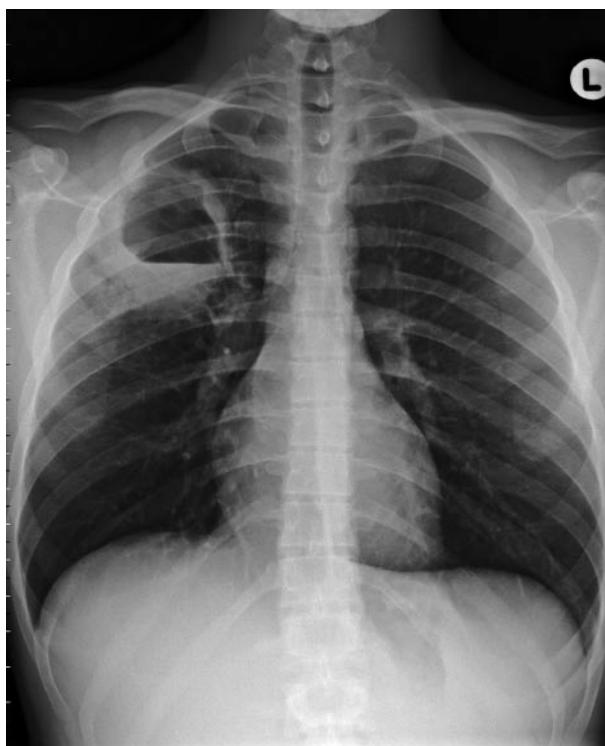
Chest radiograph taken of case patient 2 showing a large pneumatocele with an air-fluid level in right upper lobe of the lungs.
